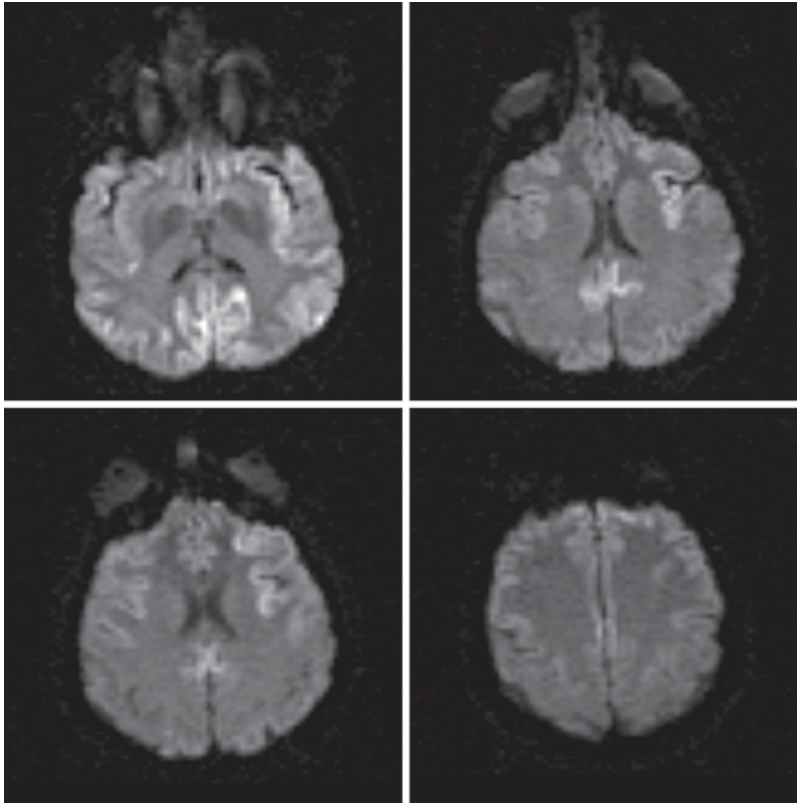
Axial, diffusion-weighted imaging (DWI) sequence MRI of 60-year-old man with 3-month rapidly progressive dementia and myoclonus showing increased
